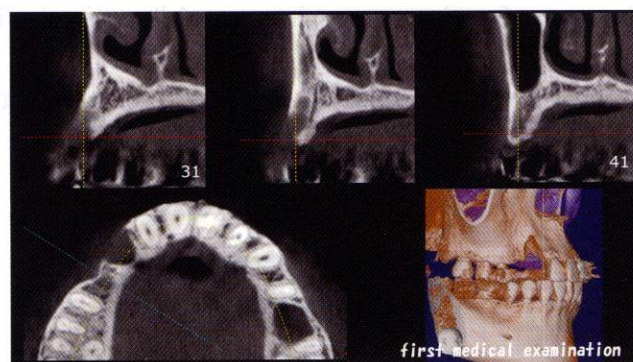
CT images at the first medical software
